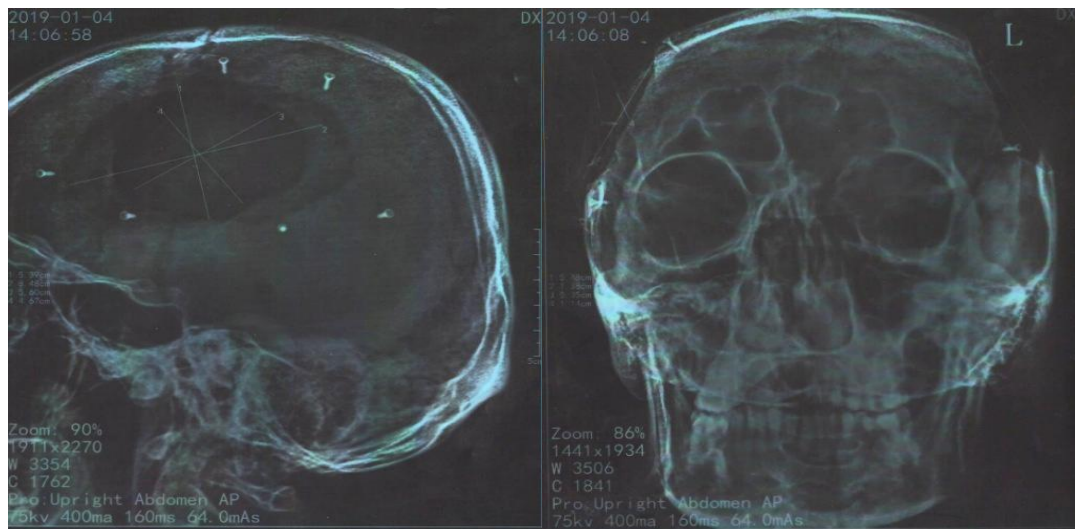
Radiograph of the patient after surgery (fastening of the carbon implant with titanium screws)
